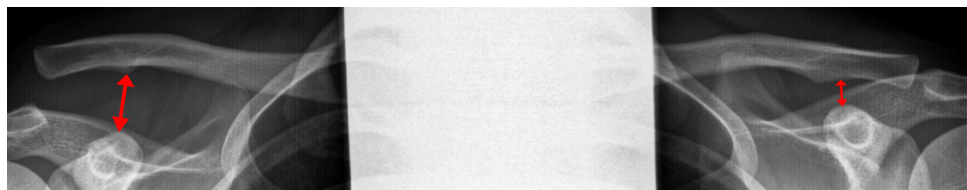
Zanca view panorama radiograph.
